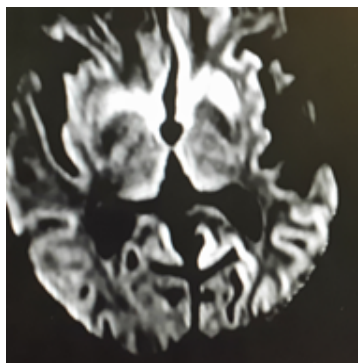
DWI (Diffusion weighted Images) shows curvilinear areas of restriction in bilateral posteromedial thalamus resembling hockey stick and consistent with pulvinar sign.
